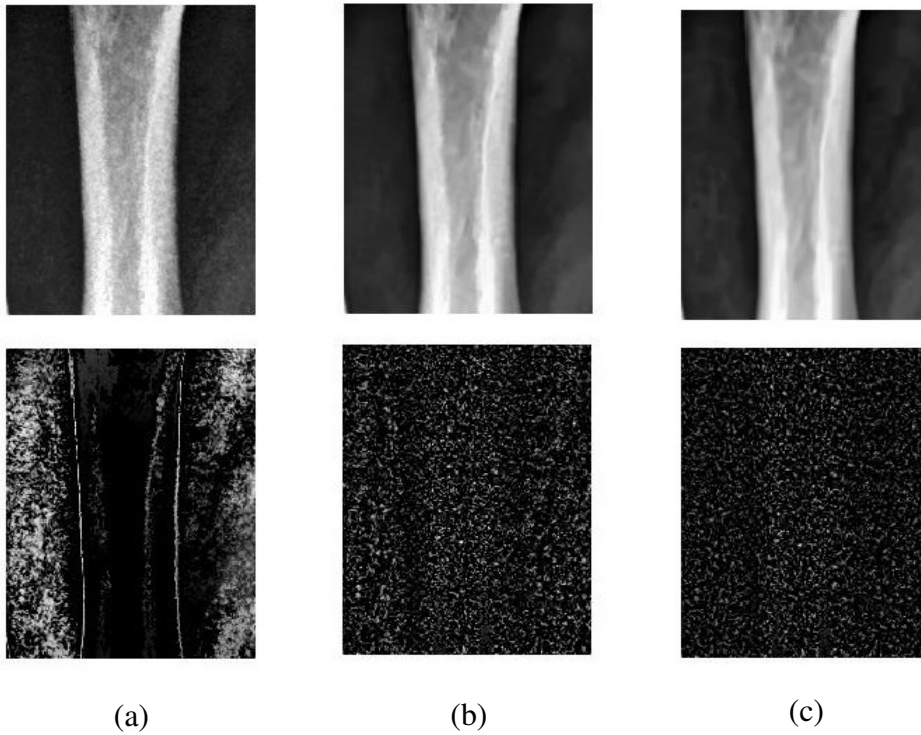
Denoising of hand radiographs: Denoised images (top row) and their difference images (bottom row) obtained using (a) bilateral filter, (b) NLPCA and (c) BM3D
